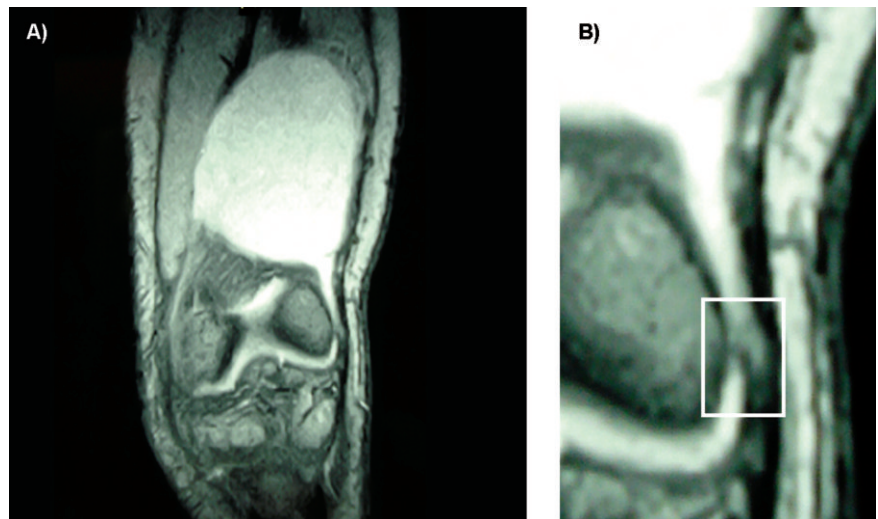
A) Coronal magnetic resonance image of knee showing suprapatellar cyst which communicates with a knee joint; B) valvular mechanism which enables one-way flow of the synovial fluid from the joint into the cyst.
